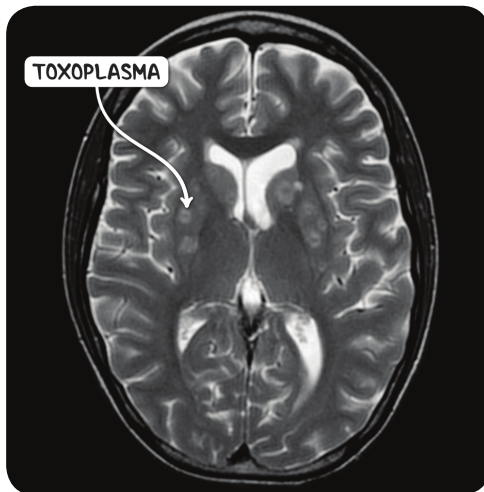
An MRI scan of the head in the axial plane demonstrating cerebral toxoplasmosis. There are numerous peripherally enhancing nodules in the basal ganglia.
